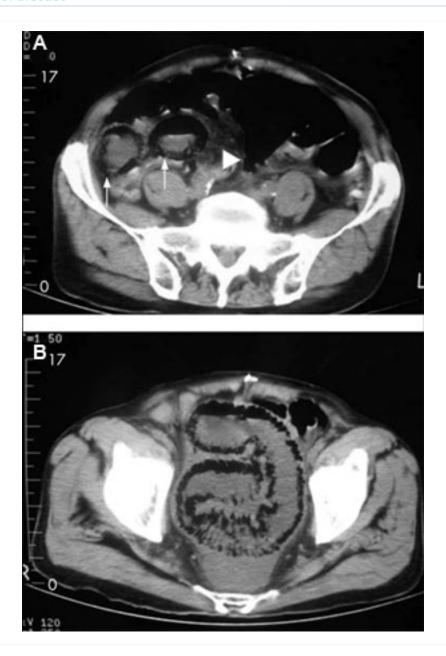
84-year-old man presenting with symptoms suggestive of ischaemic bowel disease: (A) Abdominal CT revealing a massive circumferential and band-like air formation as intestinal pneumatosis (arrows) and pronounced oedema of mesenteric fat (arrowhead) around necrotic bowel loops; (B) Another slice of abdominal CT showing long segmental pneumatosis of the small bowel
